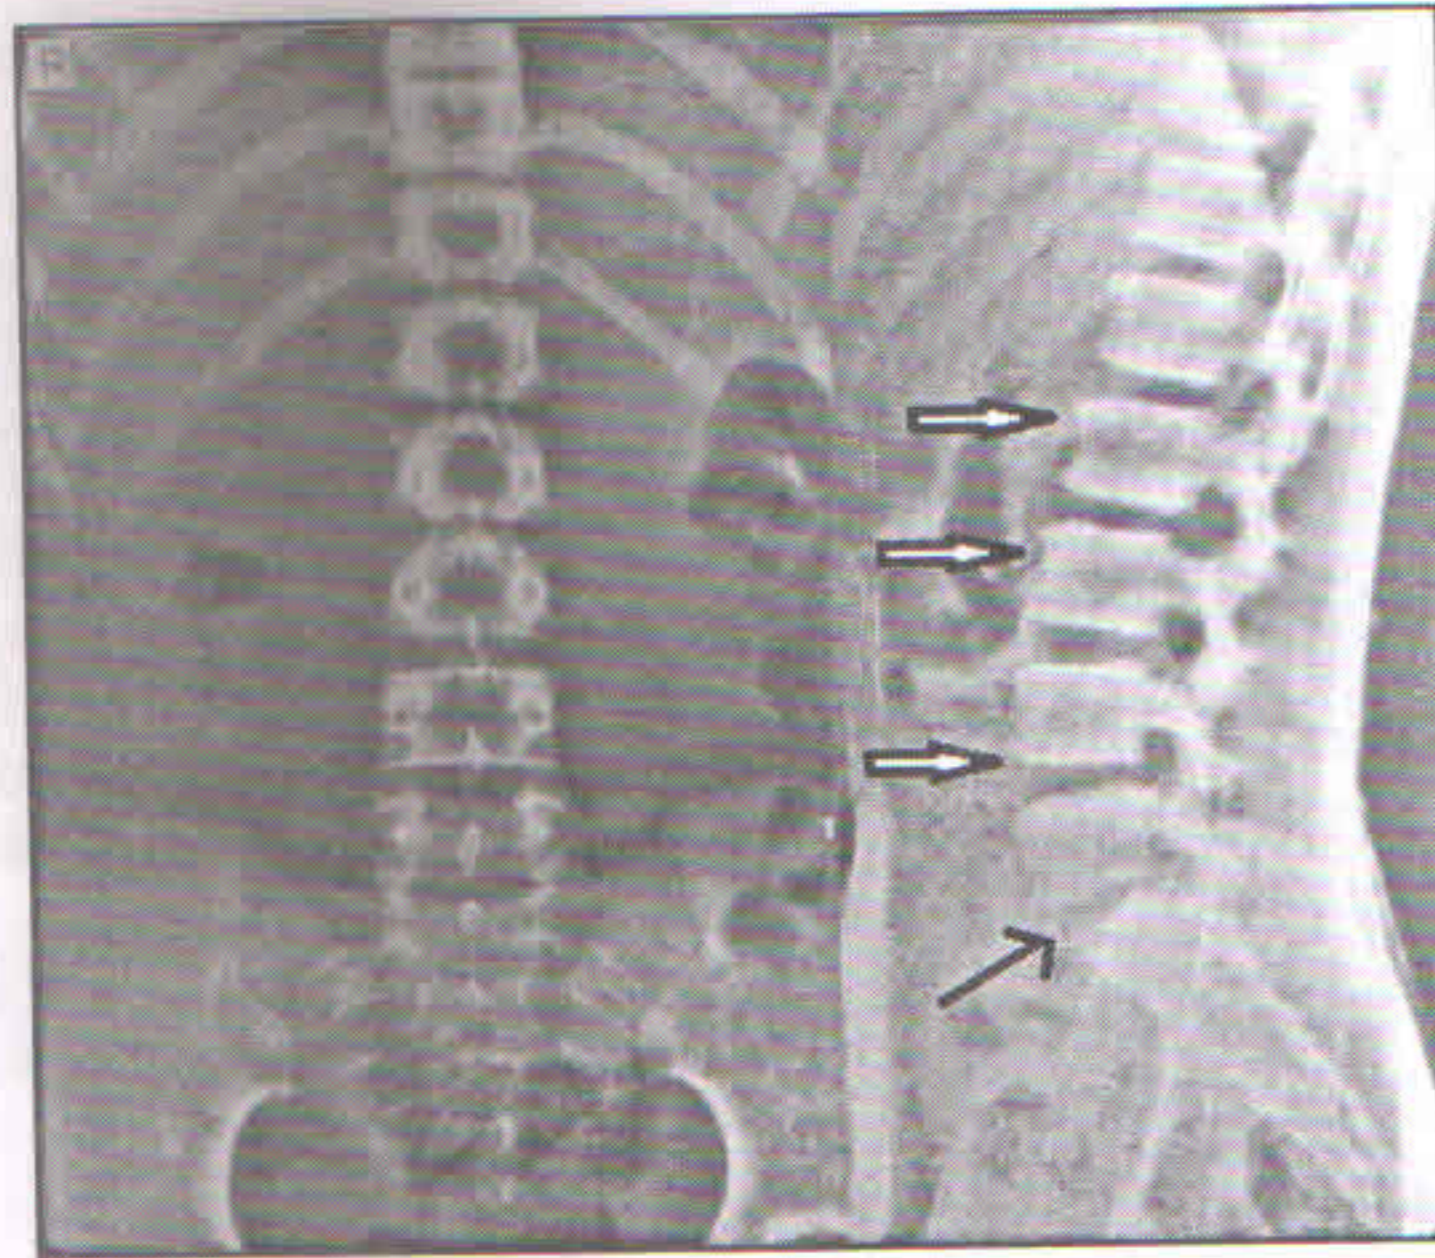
Antero-posterior and lateral radiographs of the Dorsal and lumbar spine reveal decreased disc space at L5-S1 level (arrow) and multiple small osteophyte anteriority (Block arrows). Also note the ballooning of multiple disc spaces at L2-L3, L3-L4 and L4-L5 levels.
